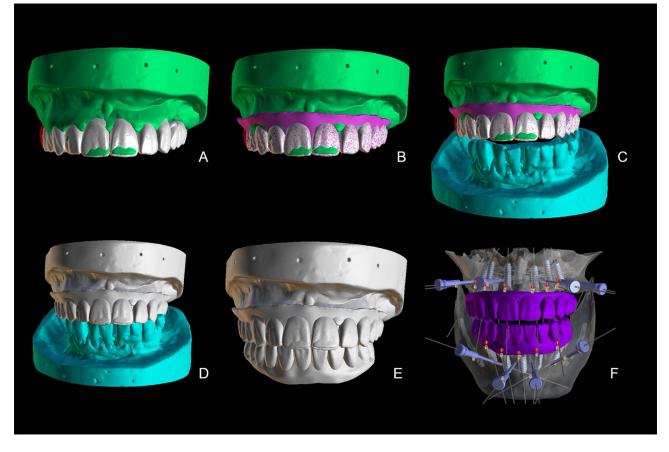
Digital planning steps. (A) Initial maxillary teeth set-up. (B) Gingival design. (C) Maxillary wax up opposing mandibular cast, which was aligned with the CBCT. (D) Transfer of maxillary wax-up to mandibular occlusion based on saved coordinates of the articulated model scans. (E) Design of mandibular wax-up. (F) Finalized maxillary and mandibular wax ups and implant planning.
